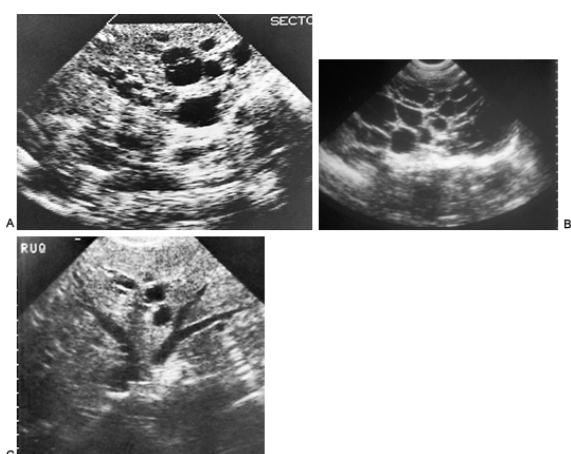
Autosomal-dominant polycystic kidney disease in two adults. A: Renal ultrasound (US) reveals multiple cysts of varying sizes in an enlarged kidney. US reveals a markedly enlarged kidney with numerous cysts of varying sizes (B) and two small cysts within the liver in a 37-year-old woman (C).
